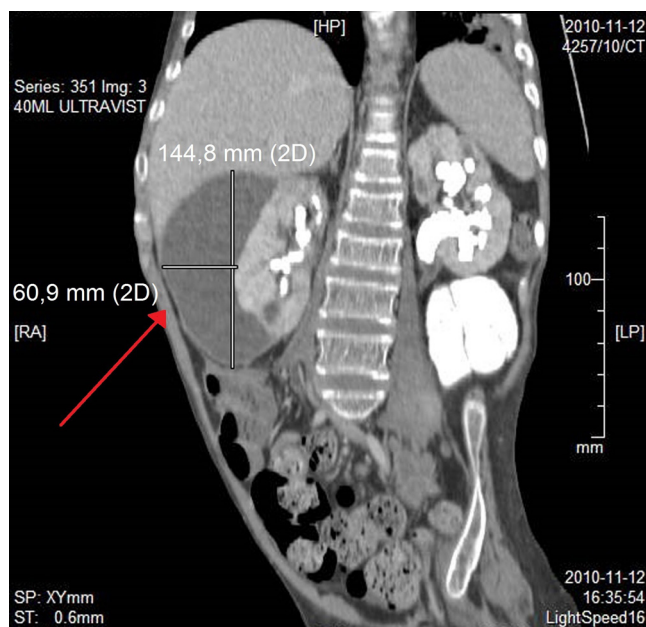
CT-scan of the abdomen. A large amount of fluid of 11–58 Hounsfield units density, under the right renal capsula (arrow)
